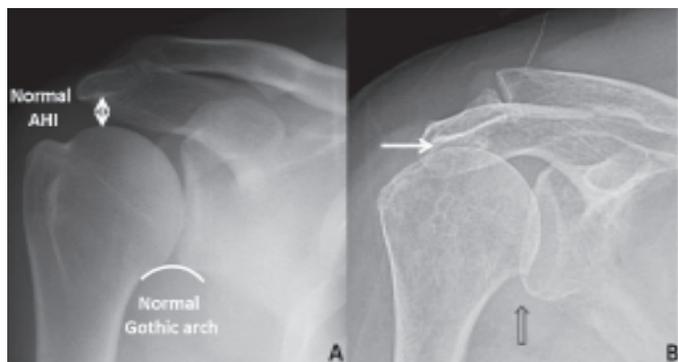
Radiograph revealing normal and reduced acromiohumeral interval. Abbreviation: AHI-acromiohumeral interval. White arrow indicating reduced AHI and another one shows broken arch.
